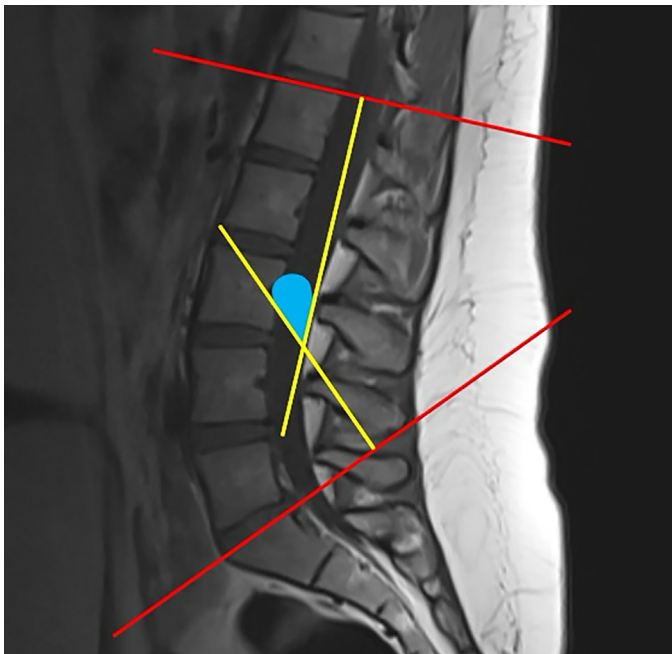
On the midsagittal plane of the T1-weighted lumbar magnetic resonance imaging series, the red lines tangential to the superior endplate of the L1 vertebra corpus and S1 vertebra corpus were drawn. Then the perpendicular lines to these red lines were drawn on the image (yellow-colored lines). Cobb's angle (presented with blue color) is formed in the intersection of the two perpendicular lines to these tangential lines.
